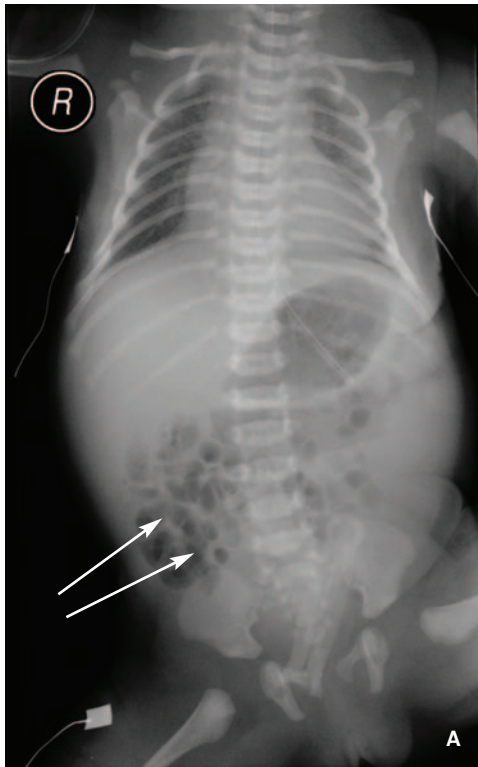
A term baby with morphological features of trisomy 21; an atrioventricular septal defect and the double bubble sign were seen on antenatal scans. (A) A plain X-ray showing a moderately dilated stomach and duodenum, with gas in the distal loops (arrows). (B) An upper GI contrast study with ballooning and dilatation of the proximal duodenum (the windsack sign, arrow) with (C) only a very small trickle of contrast seen passing into the distal duodenum after approximately 40 minutes (arrow).
